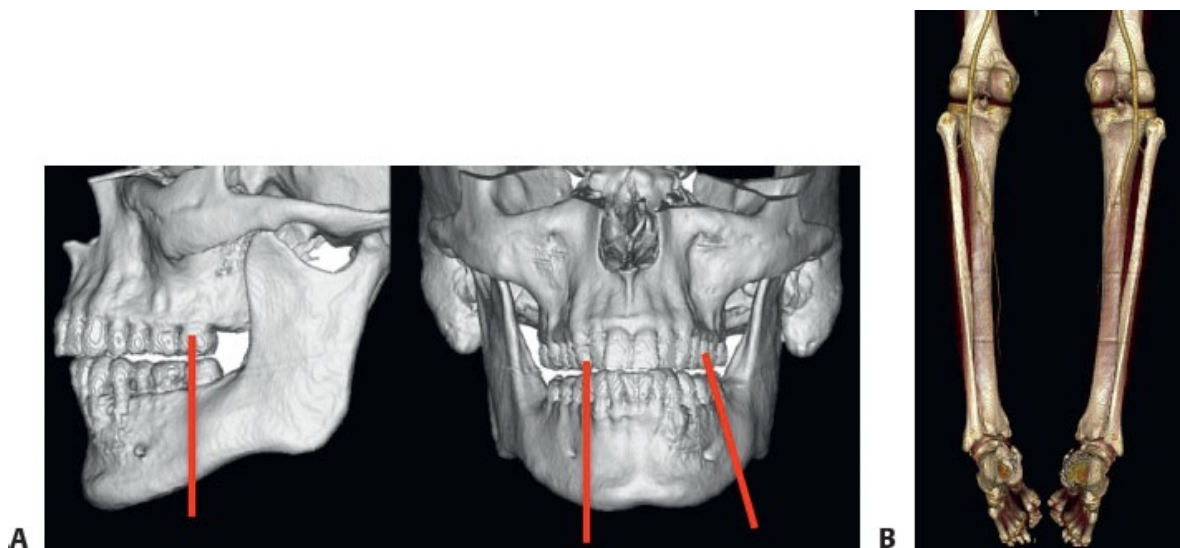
• A. Three-dimensional model of the mandible derived from thin cut CT scans demonstrating area to be resected (*red bars*). B. CT angiogram of the lower extremity and fibula anatomy.
